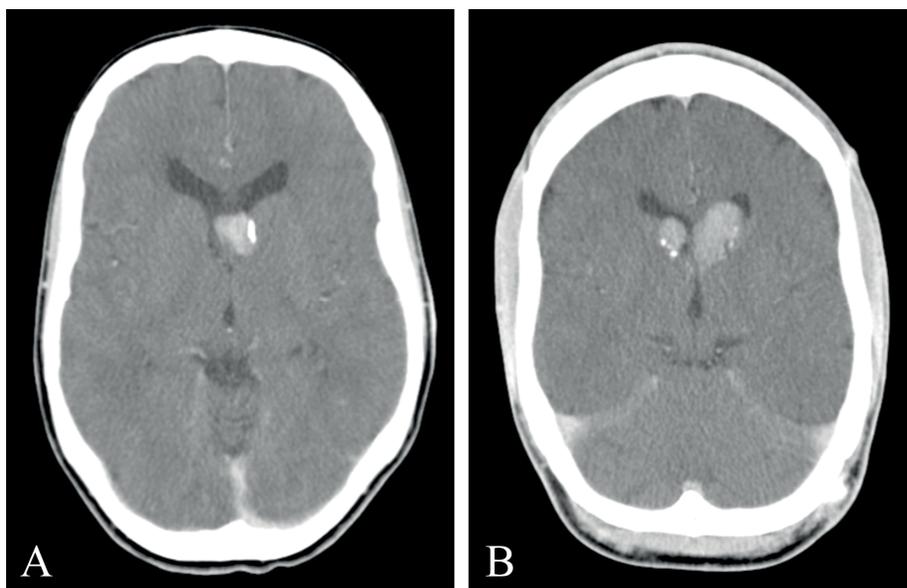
Radiological signs of subependymal giant cell tumors in patients with tuberous sclerosis complex on contrast enhanced CT scan of the brain. (a) Unilateral, left-sided enhancing lesion (arrow) near the foramen of Monroe in a 29-year-old, female patient with tuberous sclerosis complex. (b) Bilateral enhancing lesions (arrows) near the foramen of Monroe in a 24-year-old male patient with tuberous sclerosis complex.
